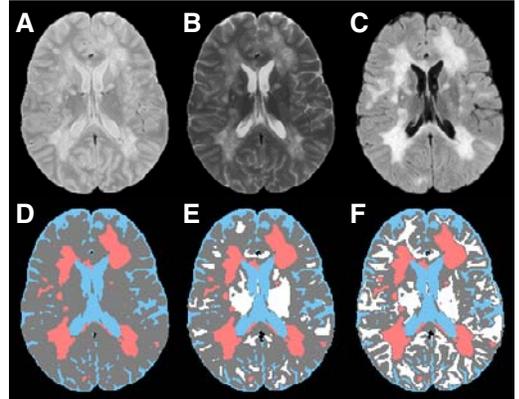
A-C: PD, T2, FLAIR, of a MS brain. D: Segmented image: CSF (blue), Parenchyma (gray), and Lesions (salmon). E: Segmented image: CSF (blue), GM (gray), WM (white) and Lesions (salmon) using method described by Sajja et al. [1]. F: Segmented image: CSF (blue), GM (gray), WM (white) and Lesions (salmon) based on present methodology (m=3).
